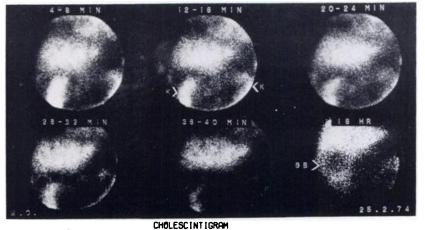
Technetium-99m-PG cholescintigram in patient with complete extrahepatic biliary obstruction due to postoperative stricture of bile duct. Scintigrams show blood pool images of heart and liver and excretion of tracer by kidneys. (Tracer does not localize in the biliary tree in complete biliary obstruction). "Hot spot" below liver represents delayed excretion by right kidney. Scintigram at 18 hr (last frame) shows radioactivity in liver and kidneys but not in gastrointestinal tract. Timeactivity curves show lack of active accumulation of tracer in liver, gallbladder, or duodenum, all curves being roughly parallel to cardiac blood pool curve. (Positioning of regions of interest for gallbladder and duodenum approximate only.)
